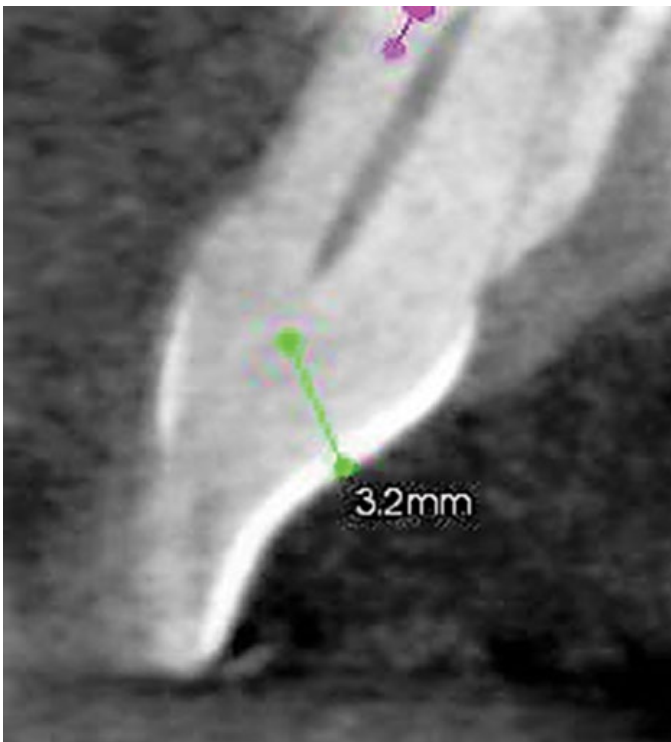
(H) The 3D CBCT imaging also enables depth measurement from lingual, so safe access depth can be achieved.
